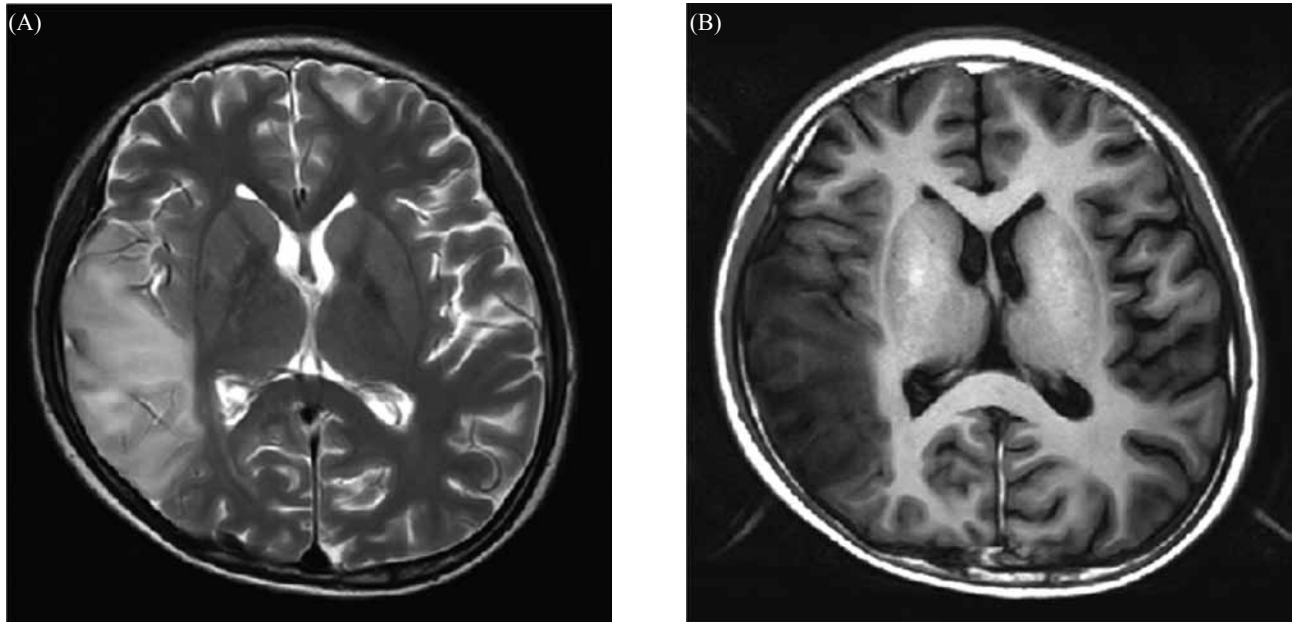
(A) T₂-weighted magnetic resonance image (MRI) shows the hyperintense right temporo-parietal occipital region. (B) T₁-weighted magnetic resonance image (MRI) shows the hypointense right temporo-parietal occipital region
